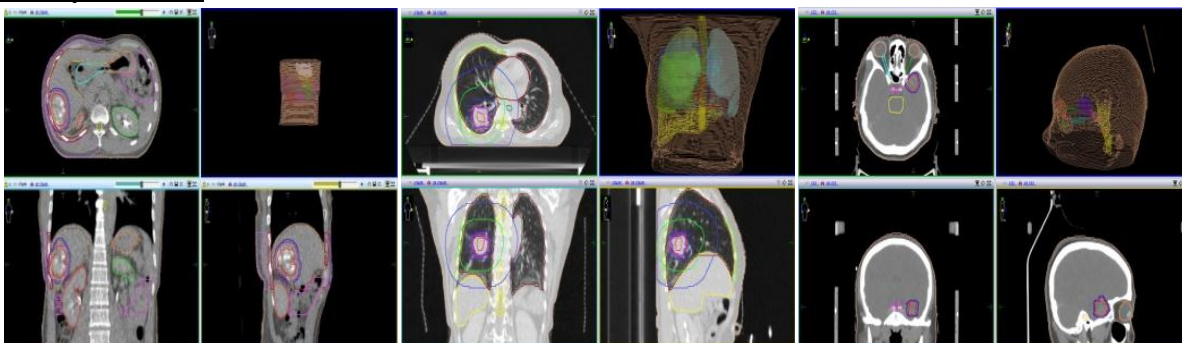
Stimulated CT images of patients.
